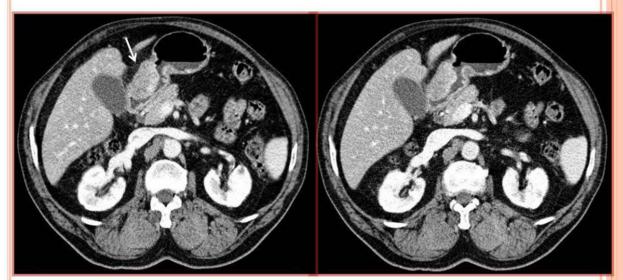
Heterotopic pancreas. Axial contrast enhanced CT images show a focal nodular thickening of the anterior wall of the gastric antrum. Biopsy was performed and pathology revealed an adenocarcinoma in an heterotopic pancreas.
